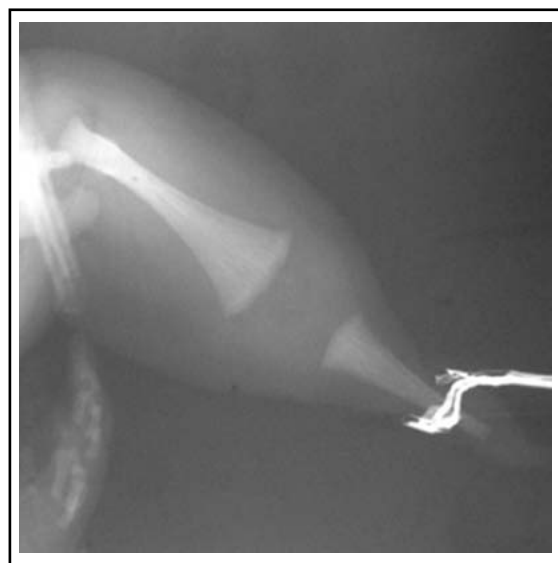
X-ray showing single femur and tibia.
